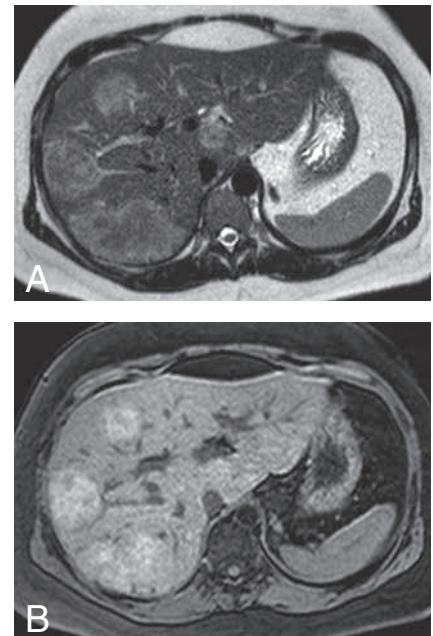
Axial T2- (A) and T1-weighted (B) MR images show multiple, sharply demarcated liver lesions with variable size. T2-weighted image shows a characteristic hyperintense rimlike band in the periphery of the lesions (A). On T1-weighted imaging lesions are hyperintense (B).
